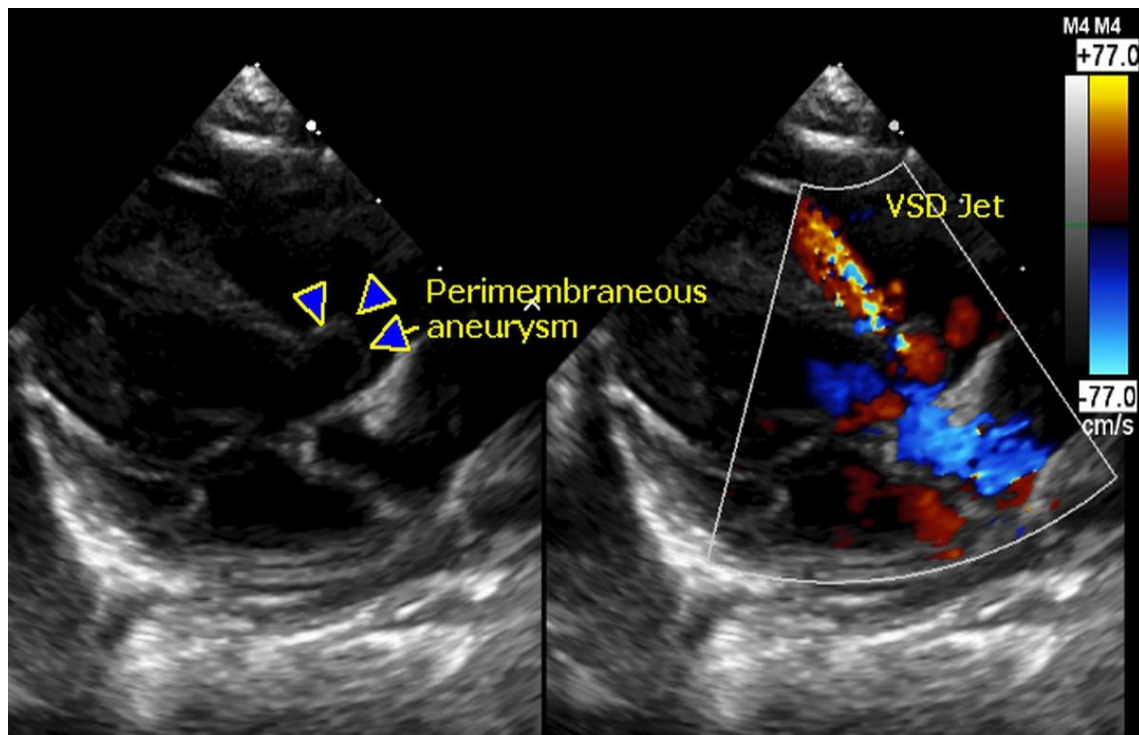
Echocardiogram shows ventricular septal defect [12]
